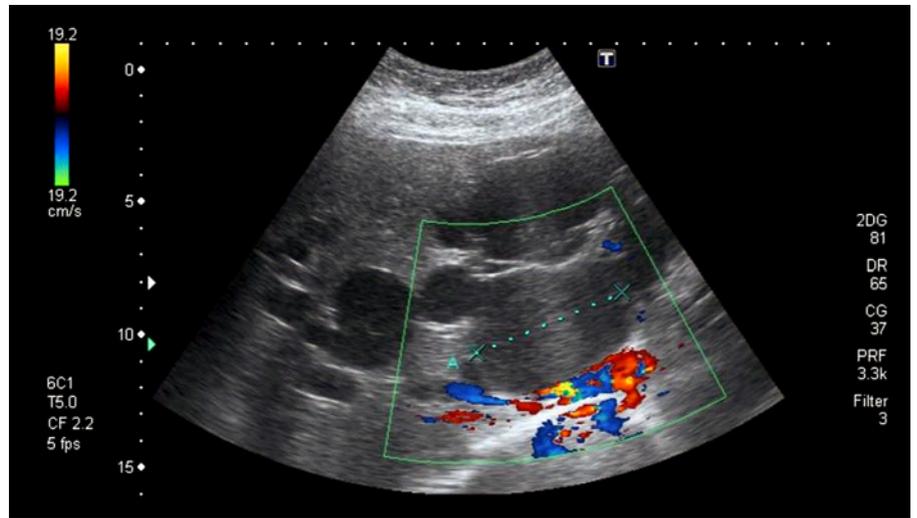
Abdominal ultrasound with Doppler imaging of the portal vein. HE. $\times 100$.
